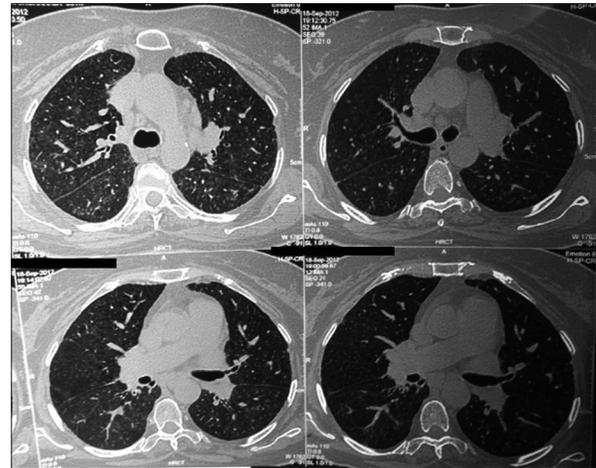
High-resolution computed tomography chest showing multiple ill-defined centrilobular opacities with ground glass opacities bilaterally before treatment
